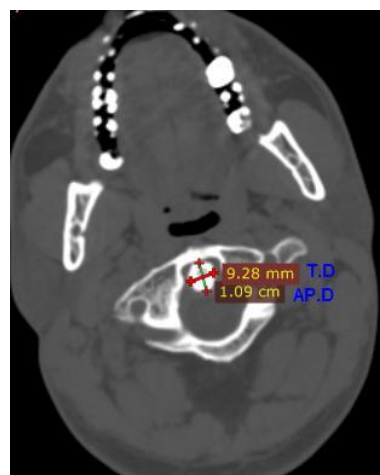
CT scan axial view at the centre of the dens shows the measurements of odontoid process T.D. (transverse diameter) and AP.D.(anteroposterior diameter).
